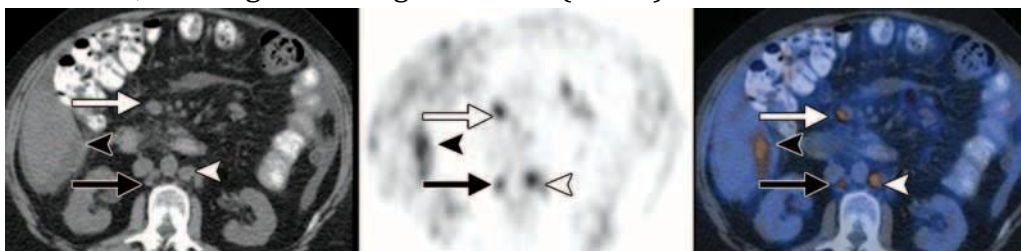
Lymph node metastasis in a 76-year-old woman with elevated CA-125 levels and a history of surgery and chemotherapy for stage IIIC ovarian serous papillary adenocarcinoma. Axial contrast-enhanced CT (left), FDG PET (middle), and fused PET/CT (right) images obtained for restaging show multiple enlarged hypermetabolic mesenteric lymph nodes (white arrow), paraaortic lymph nodes (white arrowhead), and an 8-mm hypermetabolic aortocaval lymph node (black arrow), findings indicative of metastatic nodal disease. A fluid collection in the hepatorenal fossa (black arrowhead) also demonstrates a linear irregular pattern of FDG uptake, a finding indicative of peritoneal implants.
